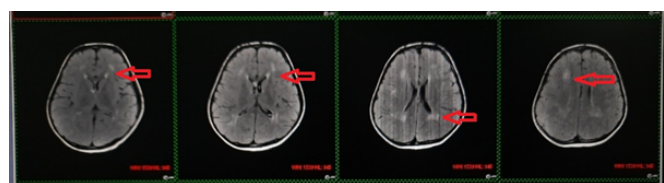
MRI showing hyper-intense areas involving white matter.
